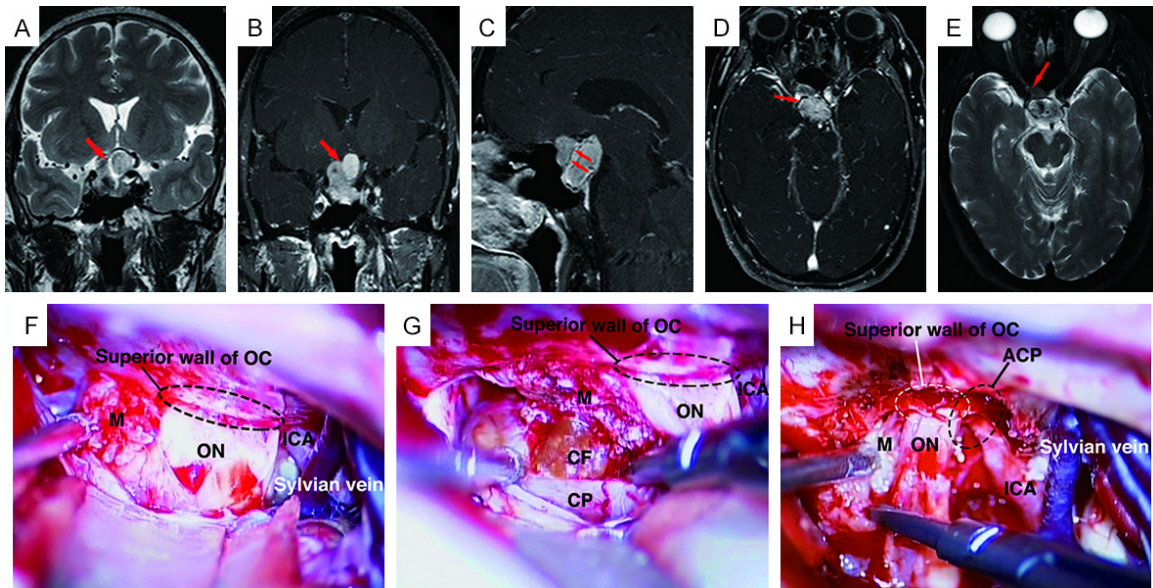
Preoperative head MRI and operative images. Coronal T2-weighted imaging (A) indicated a solid-cystic mass located in the sellar region (red arrow). Enhanced T1-weighted imaging (B-D) suggested that the mass was heterogeneously enhanced. Enhanced sagittal (C) and axial (D) T1-weighted images showing a black line (no-enhancement area) in the mass (red arrows). Axial (E) T2-weighted imaging showed that the mass is extended into the right optic canal (red arrow). Intraoperative image (F) of tumors before resection. Intraoperative image of (G) craniopharyngioma after partial resection of the meningioma. Intraoperative image (H) displayed unroofing of the right optic canal and performed clinoidectomy to decompress the right optic nerve and remove the meningioma in the optic canal. M, Meningioma, ON, Optic nerve, OC, Optic canal, ICA, Internal carotid artery, CP, Craniopharyngioma, CF, Cystic fluid, ACP, Anterior clinoid process.
